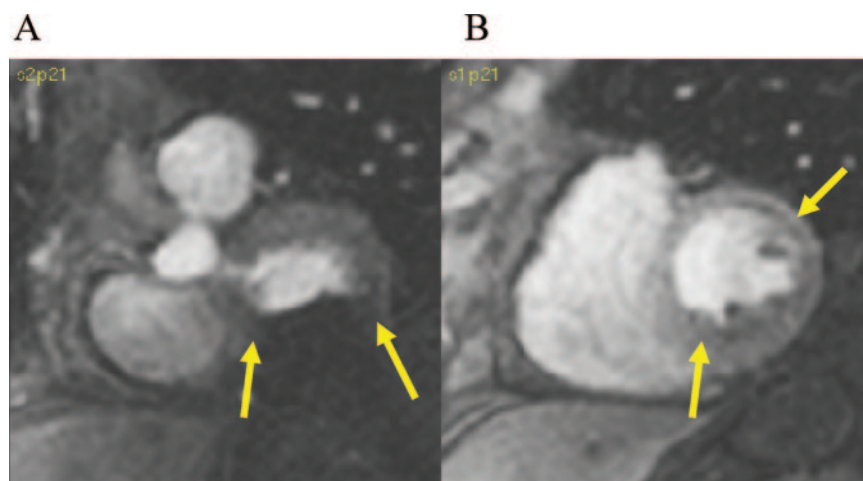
Magnetic resonance imaging rest perfusion study at basal (A) and midventricular (B) level showing a large dark expanding area in the left ventricular inferobasal wall (A, between arrows) and a mild subendocardial perfusion defect in the midventricular inferior wall (B, between arrows). Dark area is due to accumulation of hemosiderin.
